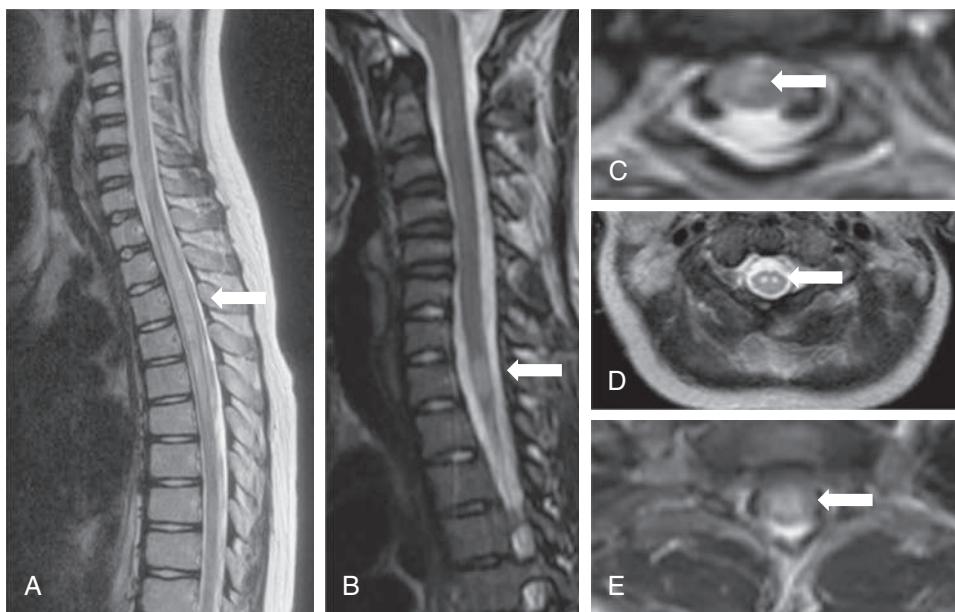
Transverse myelitis. A, Sagittal T2-weighted image demonstrates a longitudinal hyperintense spinal cord lesion in a 12-yr-old female with first presentation of AQP4-Ab-positive NMOSD (arrow). B, Sagittal T1-weighted image shows a short segment at T1-weighted (arrow) in a 14-yr-old female with ON and MS. Axial T2-weighted images of the spine with different etiologies showing typical hemicord appearance in MS (C), anterior horn cell involvement in polio (D), and holocord involvement in NMOSD (E). (C-E courtesy Dr. Felice D'Arco, Great Ormond Street Hospital, London.)
